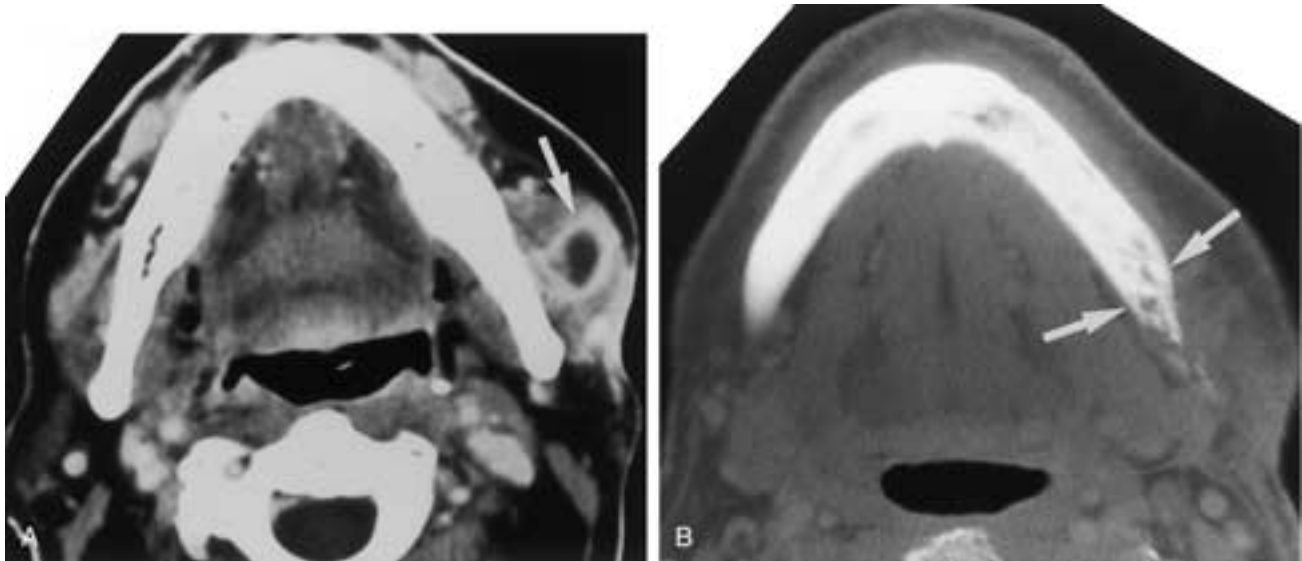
Masticator space abscess in a 75-year-old male with recurrent facial infections. A, Axial contrast-enhanced CT scan demonstrates an abscess within the left masseter muscle (*arrow*). B, CT scan with bone window settings on a slightly different plane reveals a permeated appearance of the mandible consistent with osteomyelitis (*arrows*).
